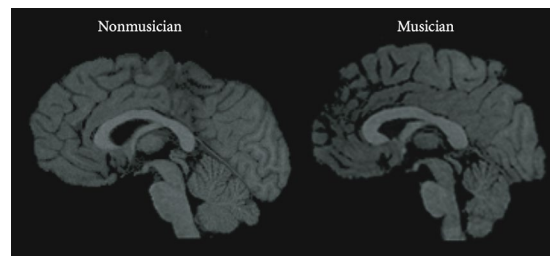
Two MRI scans showing the mid-sagittal area of the corpus callosum in a musician and a nonmusician.²⁷
